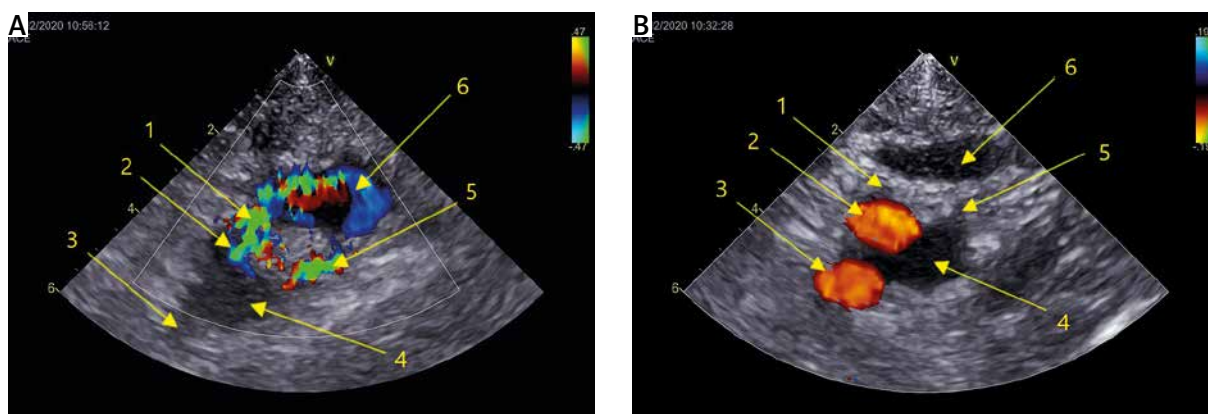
Ultrasound 2-dimensional transverse image with colour Doppler before (A) and after (B) arteriovenous fistula closure: 1 – inflow fistula channel, 2 – superficial femoral artery, 3 – deep femoral artery, 4 – femoral vein, 5 – outflow fistula channel, 6 – fistula sac
